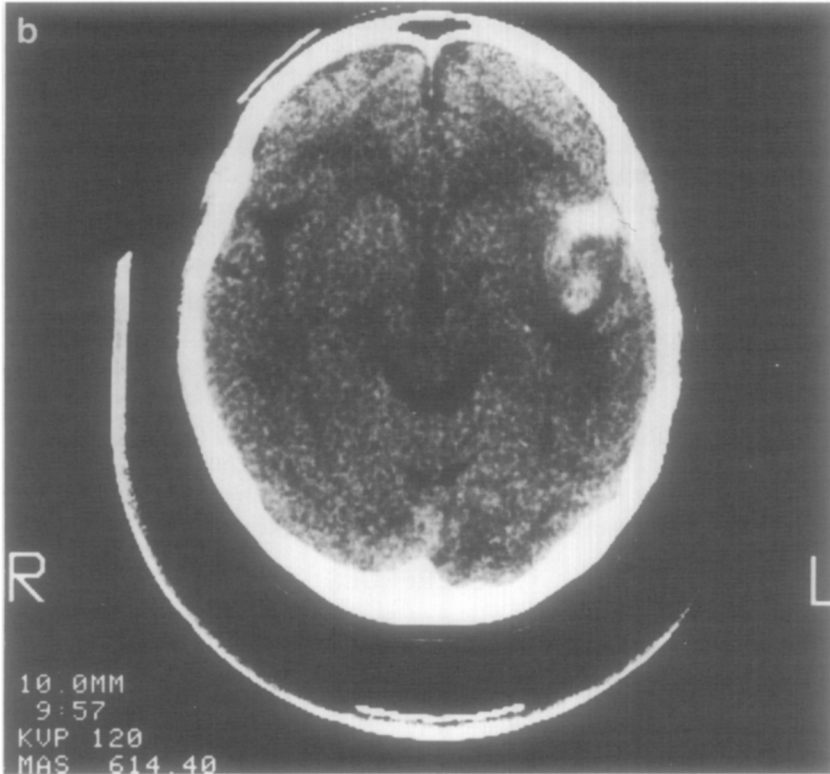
CT scan demonstrating small hemorrhagic region of contusion within the anterior left temporal lobe.
